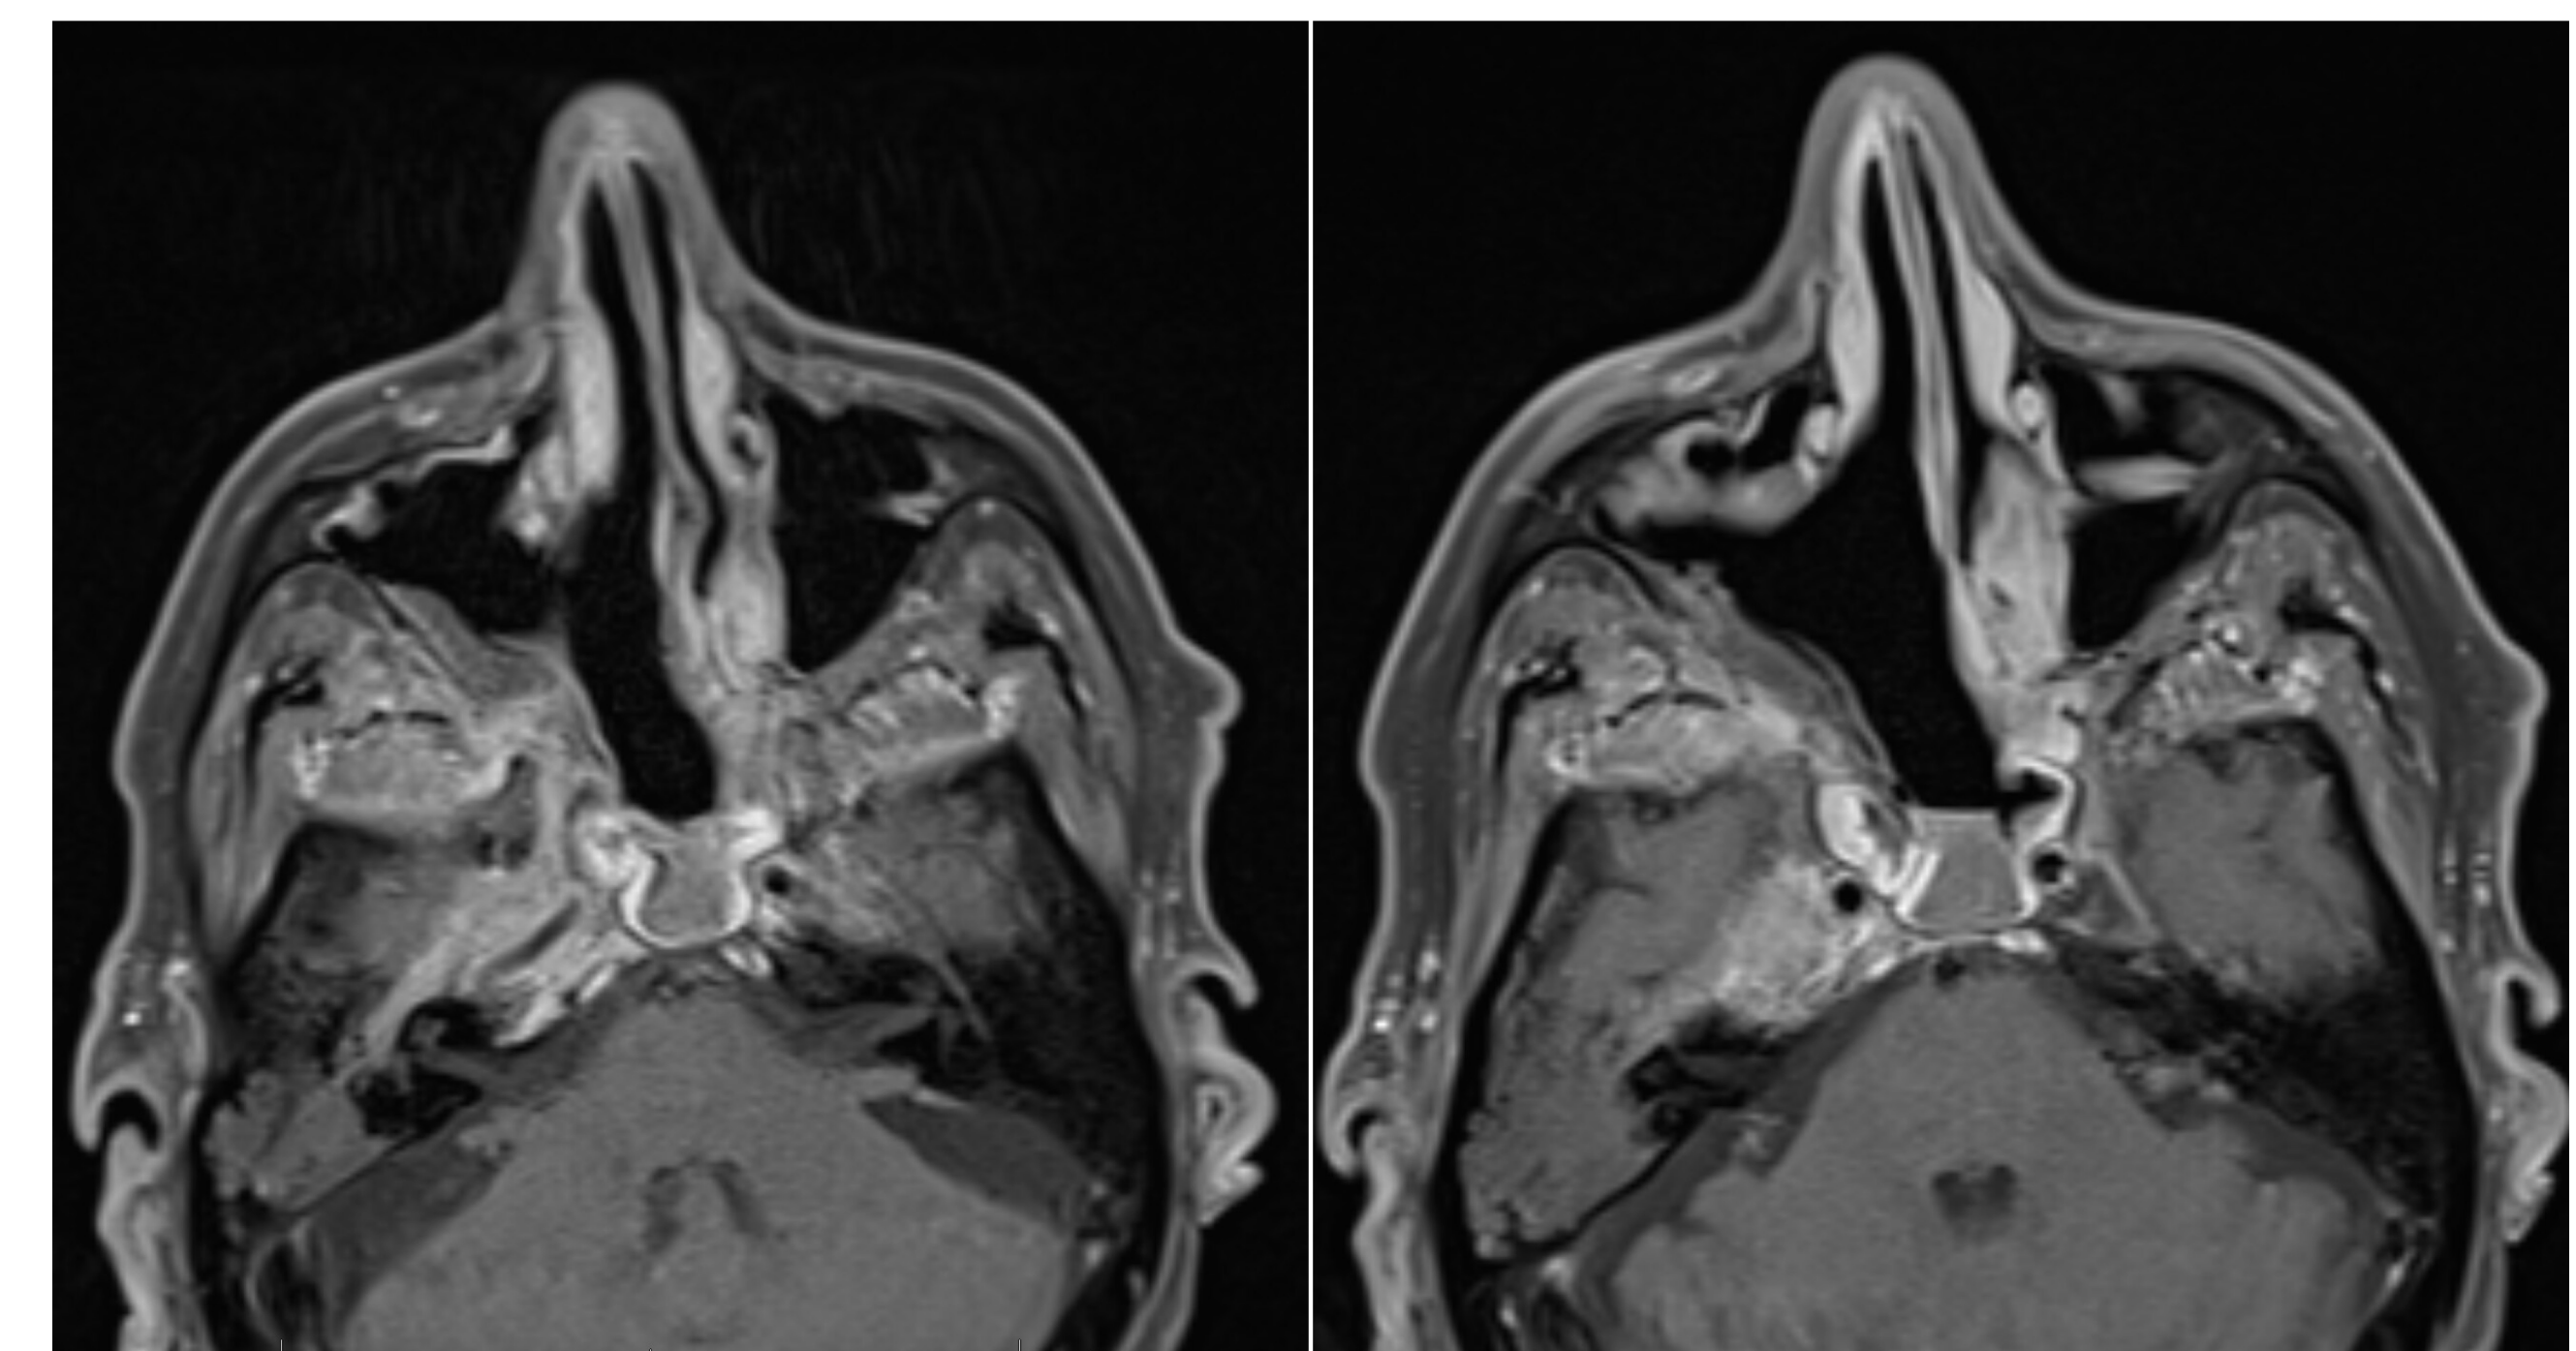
Postoperative MRI demonstrating involvement of the right cavernous sinus with disease surrounding the right internal carotid artery.
